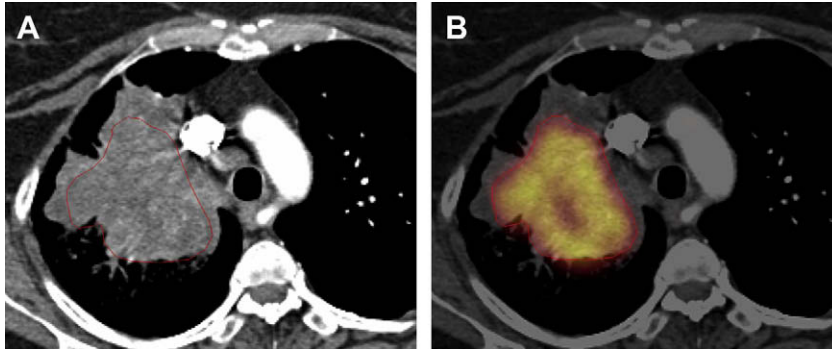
Transaxial CT (*left*) and FDG-PET (*right*) images of a clinical PET/CT study of a patient with non-small cell lung cancer of the right upper lobe. PET/CT allowed excluding associated atelectasis that was impossible using a diagnostic quality CT alone, modifying the gross tumor volume delineated for radiotherapy treatment planning.
